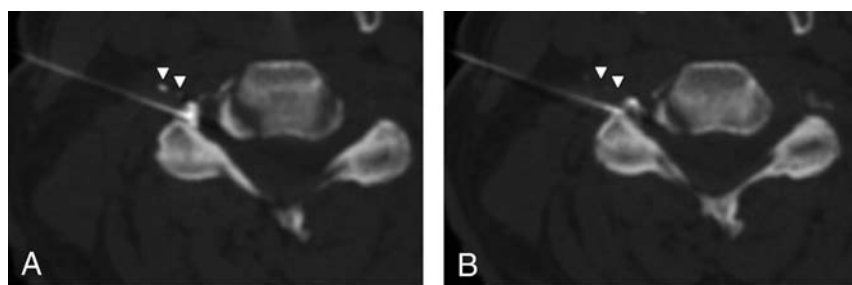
Mixed intravascular and epidural contrast injection. *A*, Intravascular injection appears as discrete foci of contrast (arrowheads) away from the needle tip and adjacent main, epidural contrast collection. *B*, The intravascular contrast almost completely disappears (arrowheads) on immediate repeat CT-fluoroscopic imaging. This rapid resolution of contrast confirmed but was not required for identification of intravascular contrast. The needle tip position is junctional on these images.
